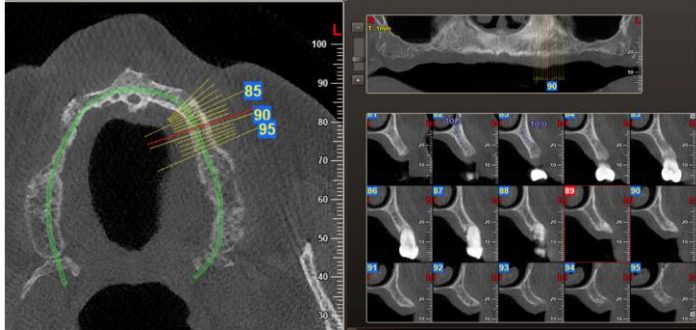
CBCT: sections of the second quadrant.
